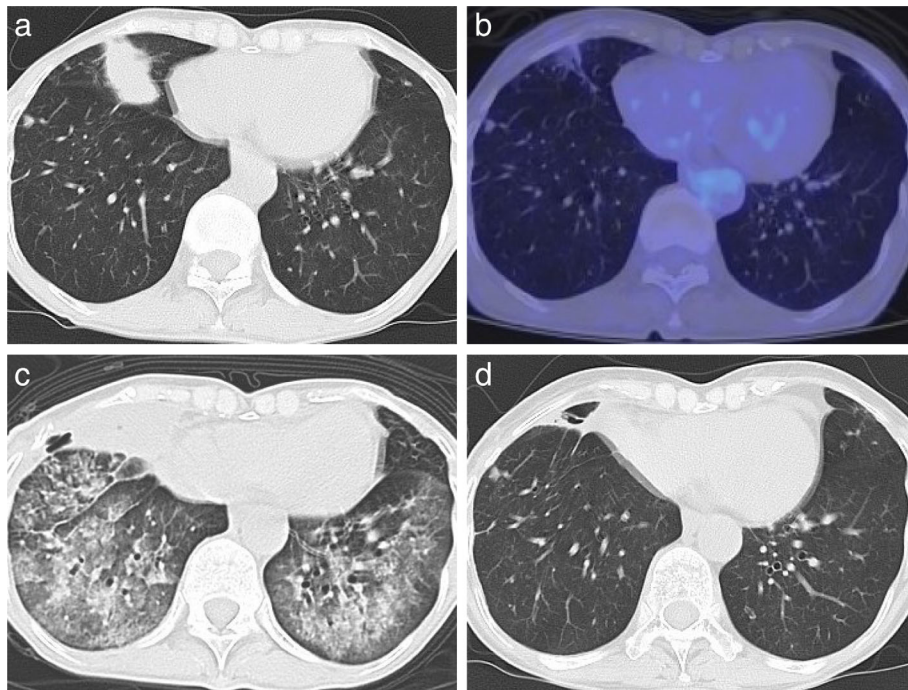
(a) Computed tomography (CT) scan of the chest showed a mass lesion in the right middle lobe and a subpleural small nodule in the right lower lobe at diagnosis. (b) Positron emission tomography showed a radiologic partial response and a metabolic complete response in the primary tumor after 12 cycles of pembrolizumab. (c) CT scan 15 days operatively demonstrated extensive bilateral ground-glass opacities and consolidation. (d) The interstitial lung infiltrates resolved after steroid therapy.
